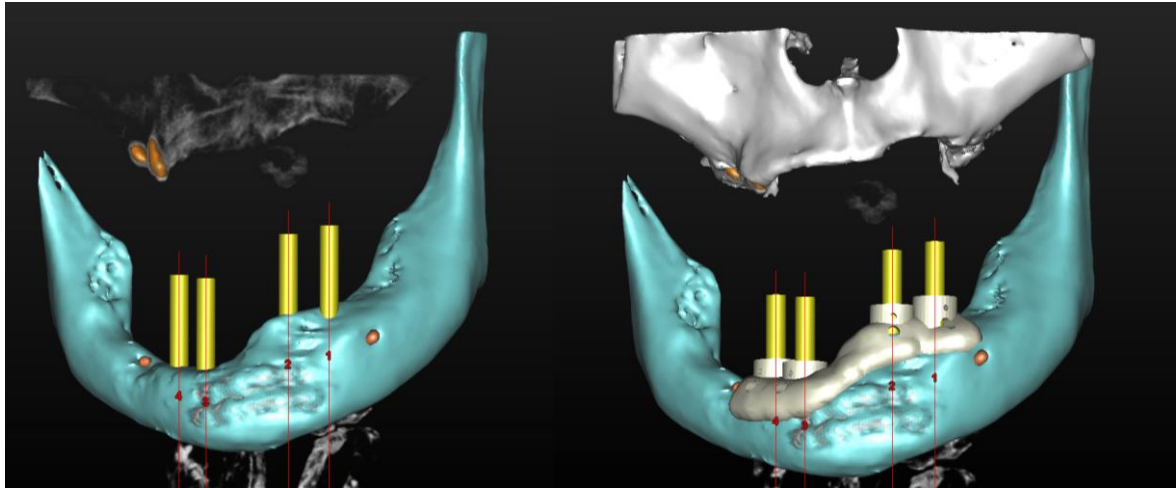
Demonstrates the design of the planned surgical bone stent planned in digital planning software using CBCT scan data.
